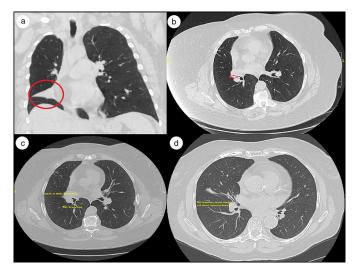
CT images. (a) Preoperative CT demonstrating right middle lobe atelectasis. (b) Preoperative CT demonstrating right middle lobe bronchial stenosis. (c) Postoperative CT demonstrating endobronchial stent in the right middle lobe orifice. (d) CT after stent removal demonstrating patent lobar and segmental bronchi.
